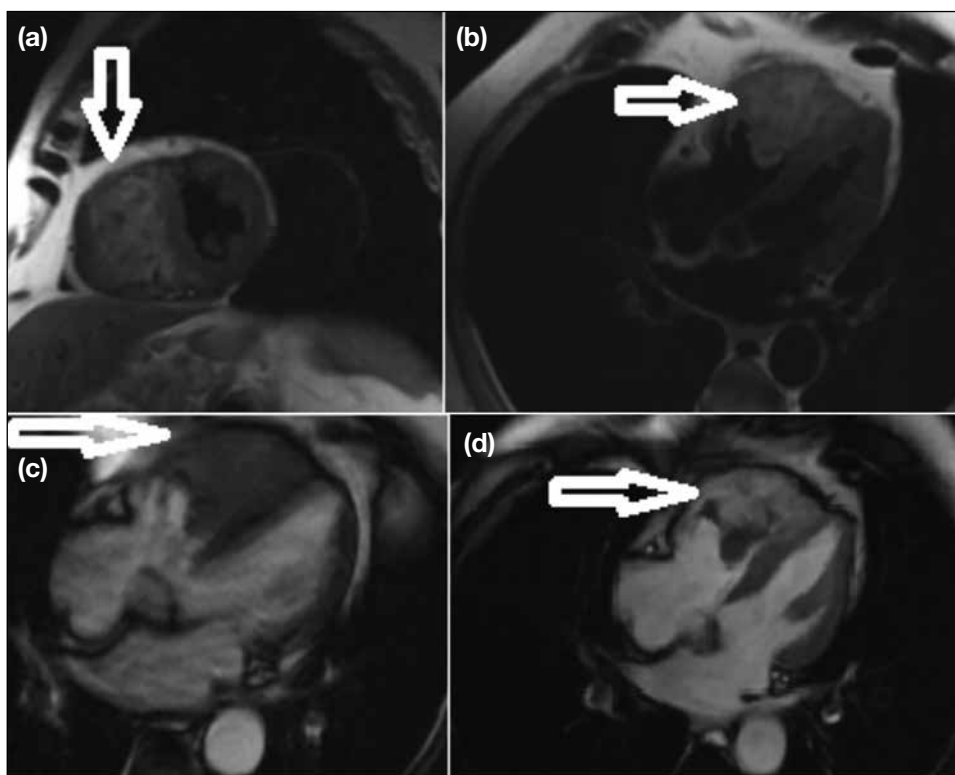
Cardiac magnetic resonance imaging of a 66-year-old male patient with known gastric cancer who was referred to the hospital with symptoms of right heart failure revealed the presence of a right ventricular mass from a gastric cancer metastasis. Two-chamber (a), dark blood four-chamber (b), pre-contrast four-chamber (c), and post-contrast four-chamber (d) images showing the mass located at the right ventricular apex extending into the right ventricular space (arrows), not only filling most of the right ventricle but also infiltrating the interventricular septum at the apical and mid anteroinferoseptal levels.
